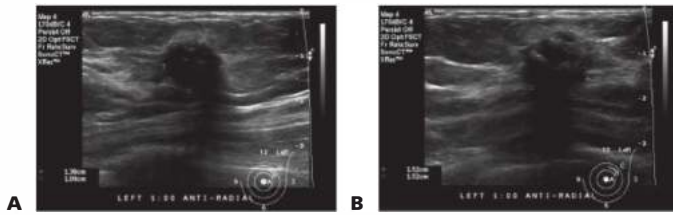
• A,B. Ultrasound images of cryoablation site 4 years after treatment. Site is smaller and has residual scar of necrotic debris where lesion had previously been.
